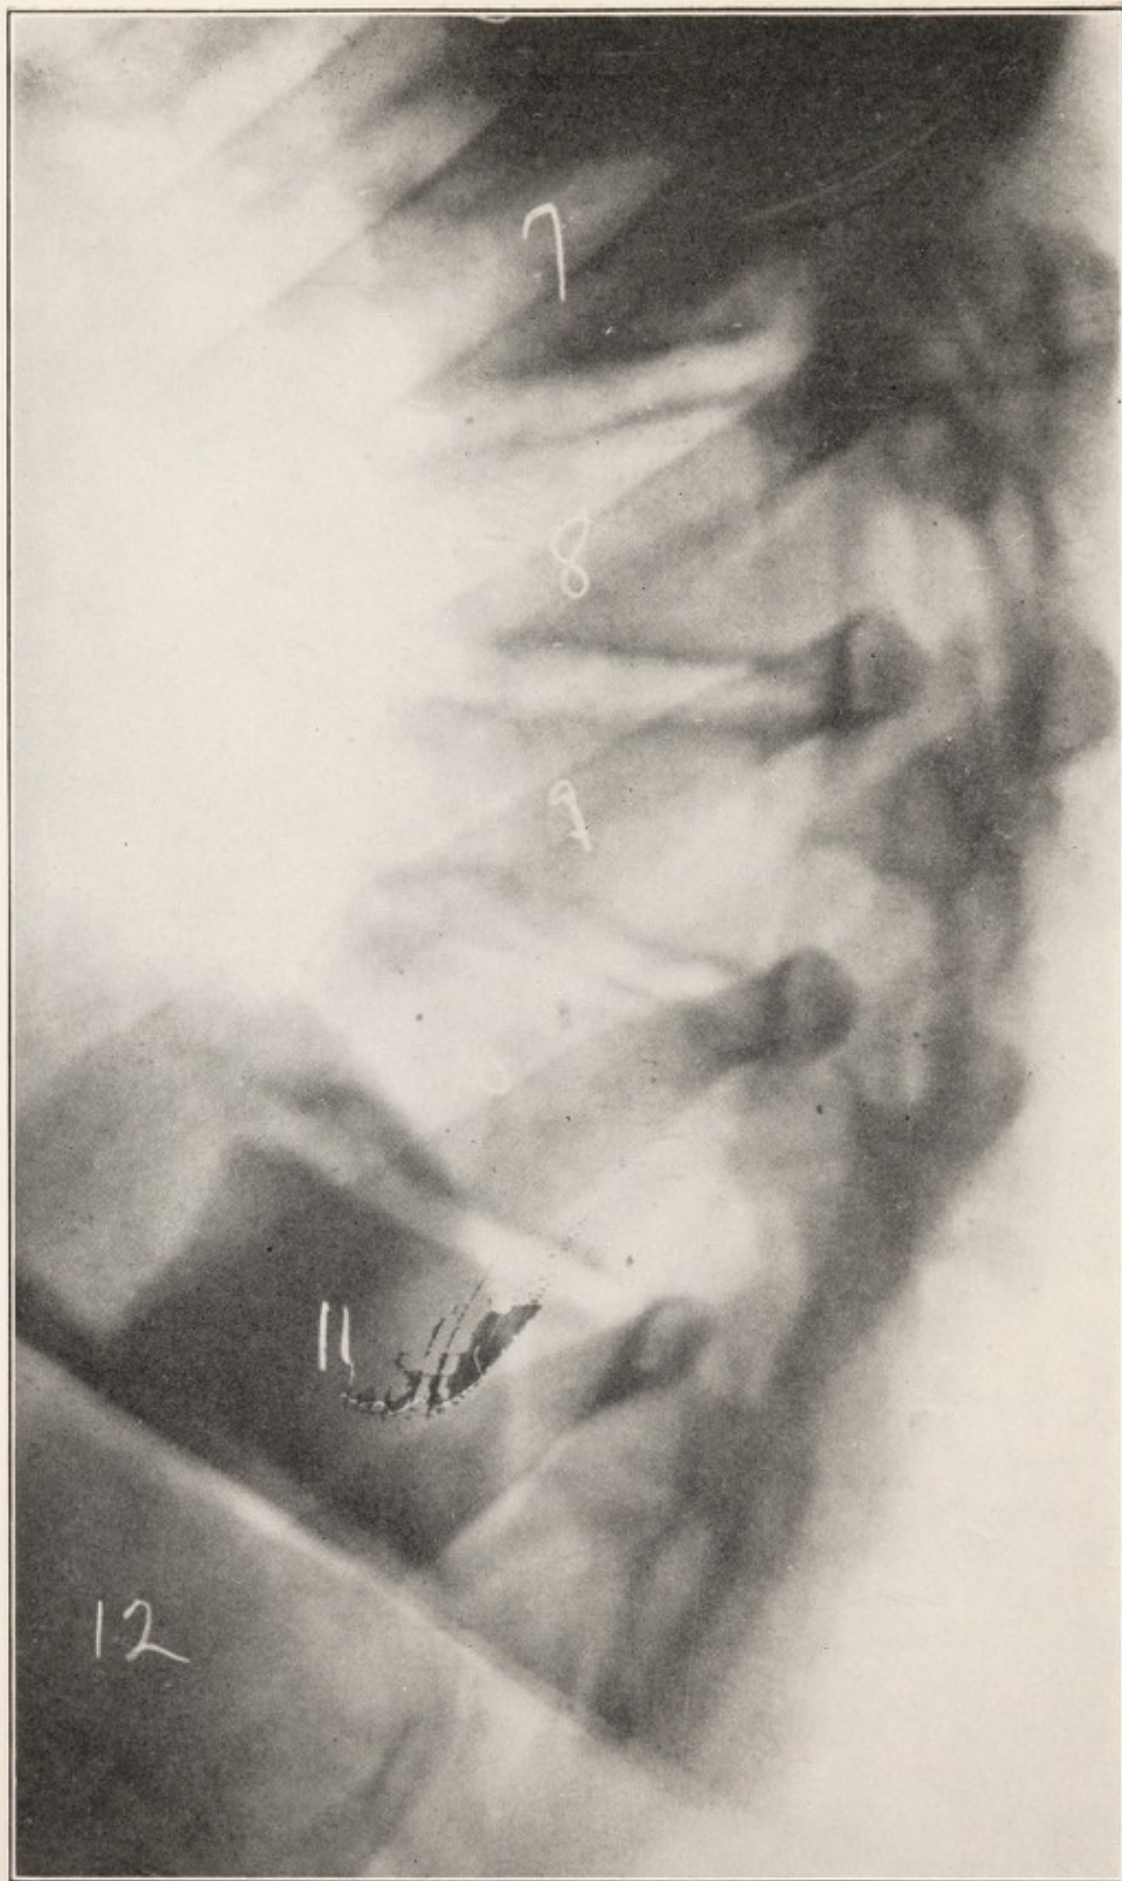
X-RAY SHOWING OSTEOCHONDritis OF SPINE WITH WEDGE-SHAPED COMPRESSION OF VERTEBRÆ.
